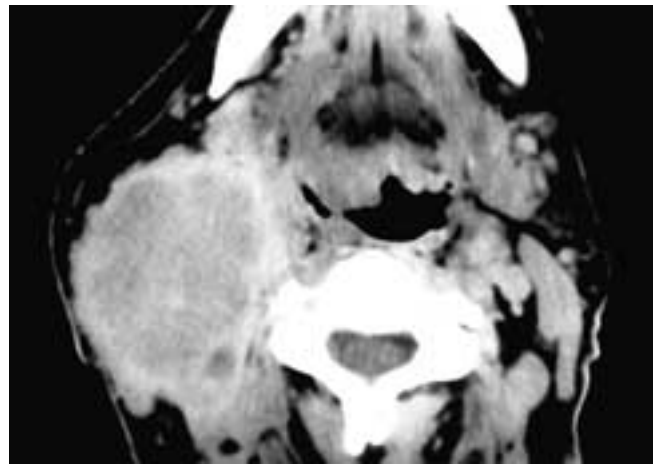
Axial contrast-enhanced CT scan shows a grossly enlarged right level II node with an enhancing rim and some involvement of the adjacent fat planes. The node is fairly homogeneous and has an attenuation less than that of muscle. Although metastatic squamous cell carcinoma nodes can have similar-appearing capsular enhancement with extracapsular disease, it would be unusual to find a node this large without central necrosis. This patient had large cell lymphoma.
